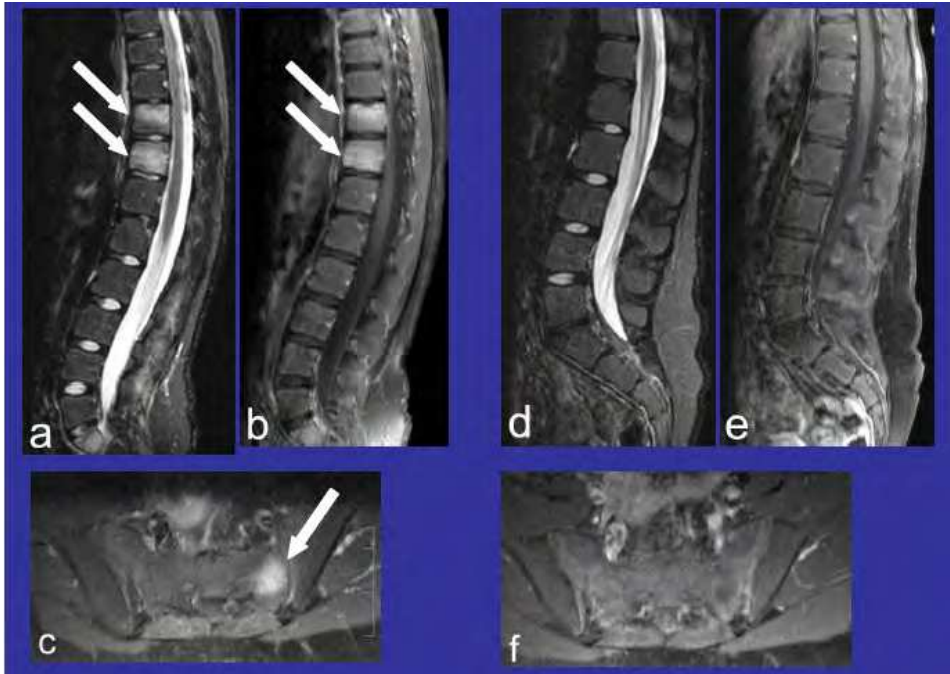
CRMO involving the spine in a 10-year old girl. (A-C). MR images at sagittal plane (A and B) and axial plane (C) using STIR (Short TI inversion recovery) sequence (A) and post-contrast spin-echo T1-weighted sequence (B and C) reveal abnormal signal in vertebral bodies of T10, T11, and S1 (arrows), as well as sacral ala (arrow). (D-F). MR images using the same technique obtained 5-months later. Complete resolution of the previously seen abnormal signal (Miettunen, Wei et al. 2009).
